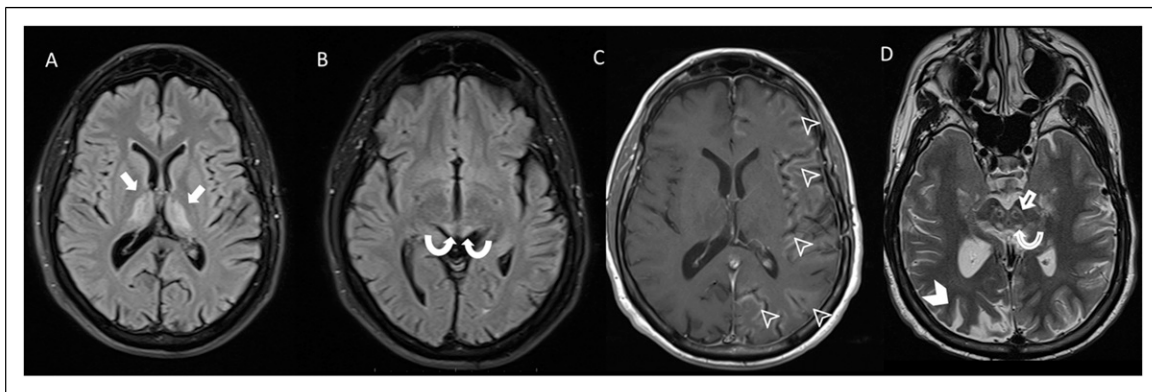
46-year-old male presented with progressive encephalopathy and aphasia. A and B. Axial T2-FLAIR-weighted sequences show hyperintensity of the thalami (arrows) and superior colliculi (curved arrows). C. Post-contrast axial T1-weighted shows gyriform enhancement (arrowheads) in the left hemisphere cortex with a "stroke-like" appearance. D. Axial T2-weighted image shows hyperintensity around the red nuclei (open arrow) and inferior colliculi (curved arrow). Right occipital lobe volume loss is also present (arrowhead).
